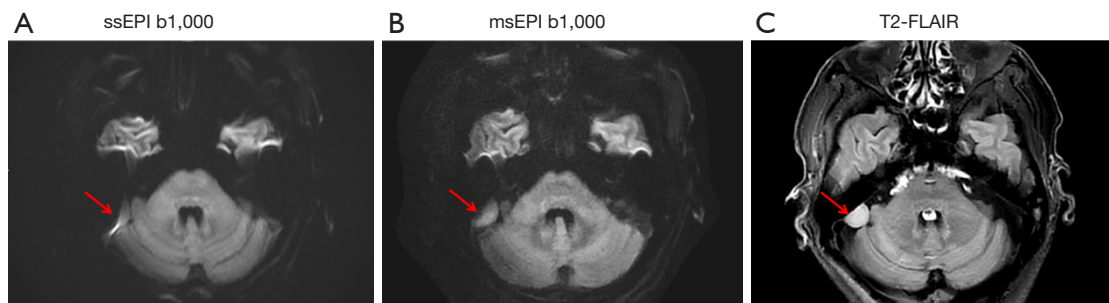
A 49-year-old female patient with meningioma. (A) The meningioma lesion (red arrow) on ssEPI DWI. (B) The meningioma lesion (red arrow) on msEPI DWI. (C) The meningioma lesion (red arrow) on T2-FLAIR. The meningioma lesion appeared less distorted on msEPI DWI than on ssEPI DWI. ssEPI, single-shot echo-planar imaging; b1,000, $b=1,000 \text{ s/mm}^2$; msEPI, multishot echo-planar imaging; T2-FLAIR, T2-weighted fluid-attenuated inversion recovery; DWI, diffusion-weighted imaging.
